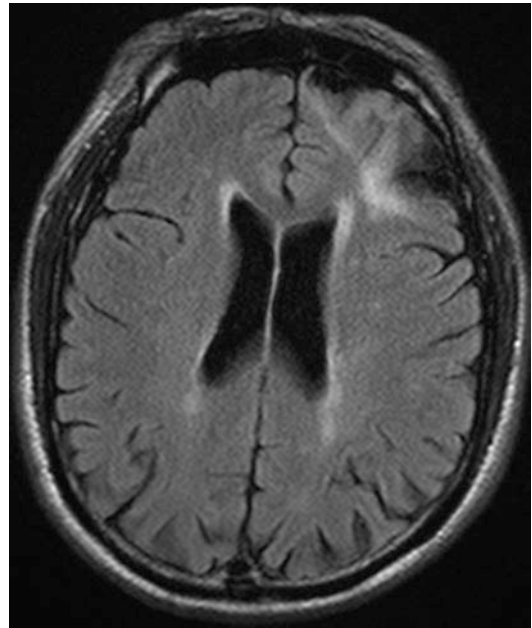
MR images in patients with watershed infarct dementia. Axial FLAIR images show left anterior watershed infarction in a 74-year-old man who showed transcortical motor aphasia and executive dysfunctions
